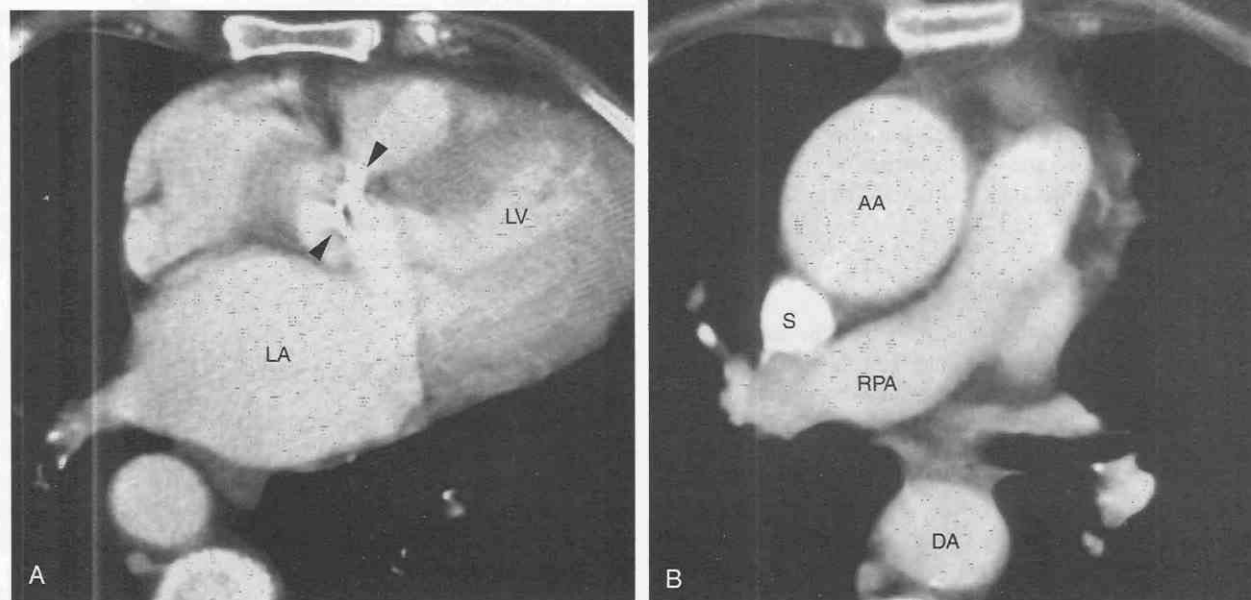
Degenerative aortic stenosis in a 73-year-old woman. Axial contrast-enhanced CT images show (A) calcification of the aortic valve (arrowheads) and (B) dilatation of the ascending aorta. Note the thickened myocardium of the left ventricle. AA, ascending aorta; DA, descending aorta; LA, left atrium; LV, left ventricle; RPA, right pulmonary artery; S, superior vena cava.
